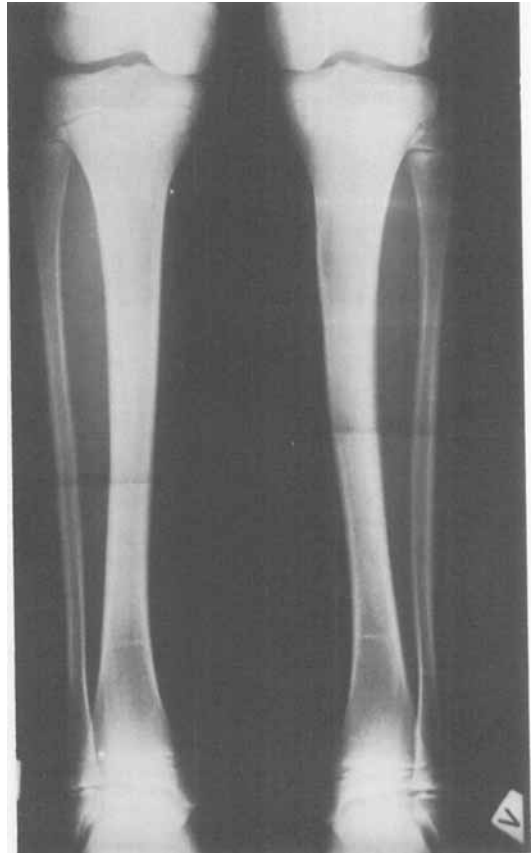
An X-ray taken 8 years after the accident, when the patient was 13 years of age. The previously injured leg, seen on the right, has a slight S-shape, with a more oblique central part of the shaft. Owing to the corrective growth, the valgus angulation has decreased from  $14^\circ$  to  $6^\circ$ . Clinically there was merely a hint of the valgus deformity. At follow-up the patient had no complaints (Case 3). (The solid transverse lines are explained by the X-ray having been taken with two films in each cassette).
